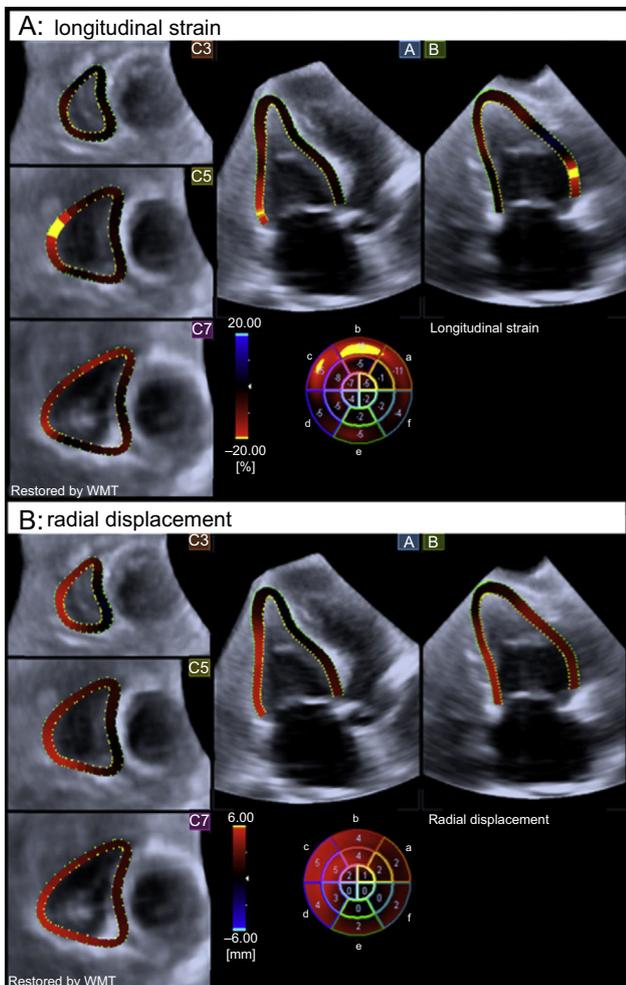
End-systolic right ventricular global longitudinal strain (A) and radial displacement (B) color-coded 3-dimensional-speckle tracking echocardiography performed in a patient with cardiac involvement. Note the significantly altered myocardial mechanics of the right ventricle, according to the color-coded bar. WMT, wall motion tracking.
